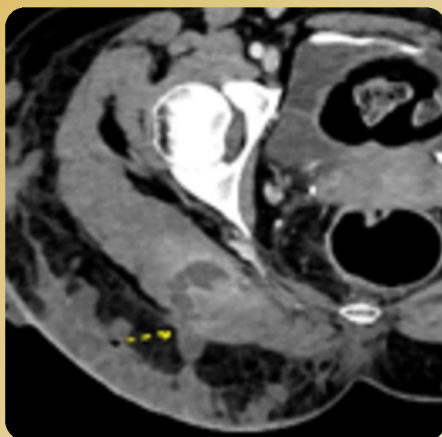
Intramuscular collection with subcutaneous fistulization on CT-scan
